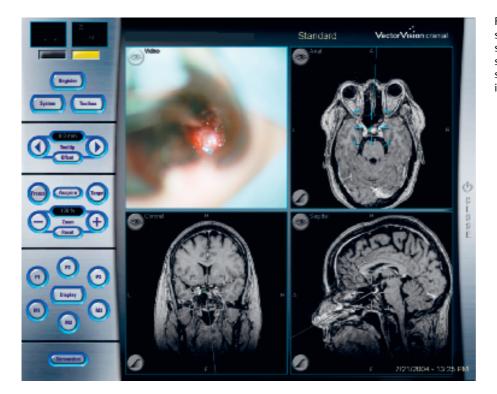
View approaching the sphenoid sinus with enlargement of the hiatus sinus sphenoidalis and at this point the navigation system is used to confirm the visualized structures with the preoperative MRI images.
